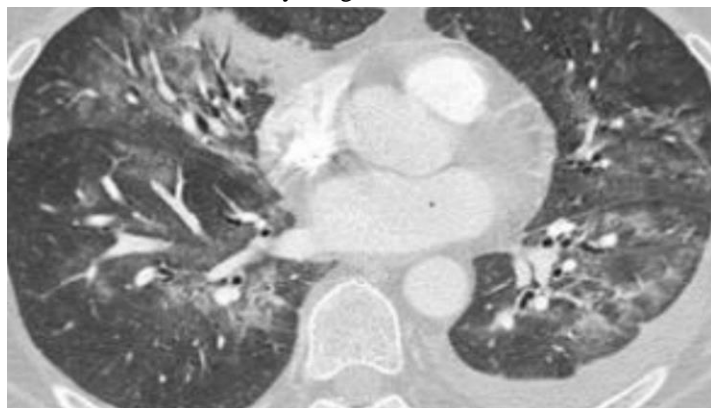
CT scan demonstrated multifocal consolidation.
